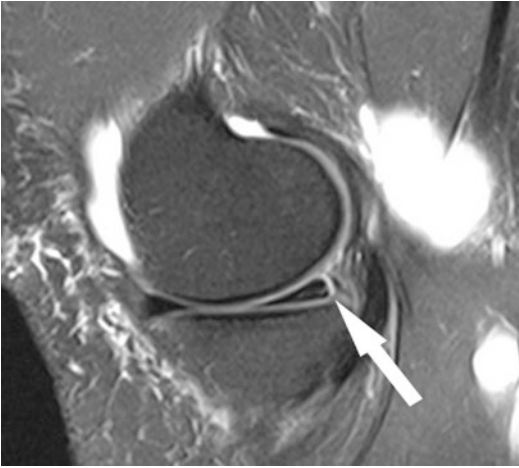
Sagittal fat-saturated T2-weighted sequence showing medial meniscocapsular separation with thin fluid interposed between the posterior horn of the medial meniscus and capsule (*arrow*) [28]
